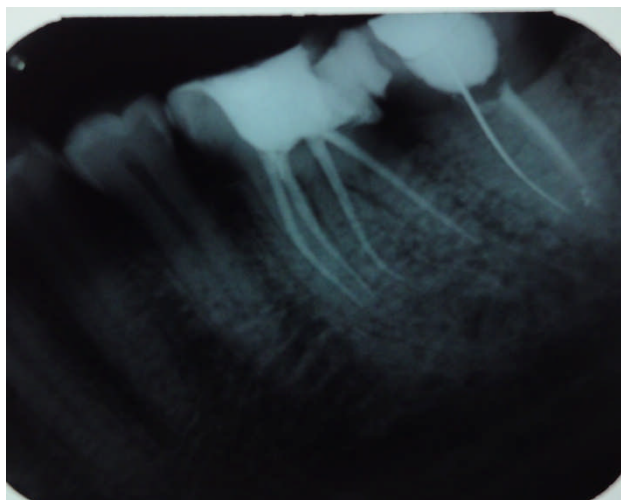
radiograph showing obturation of case 2
